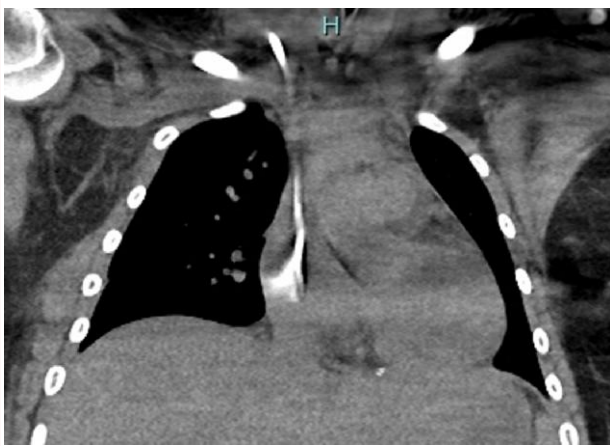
Chest computed tomography image of the patient after cardiac tamponade diagnosis. Even in the presence of artefacts, it is possible to appreciate how the tip of the catheter points towards the free wall of the right atrium.
